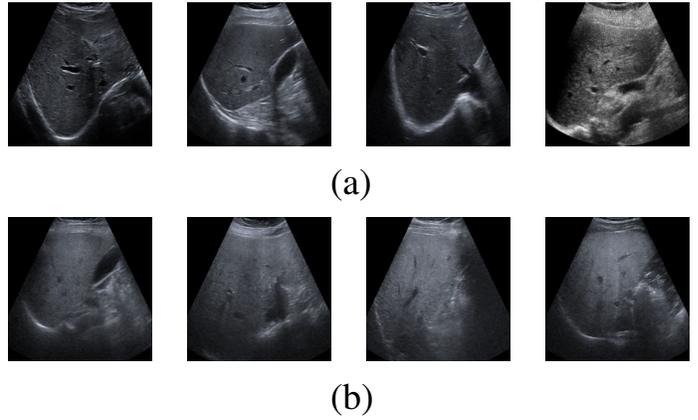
(a) Ultrasound images of liver under normal conditions, (b) Ultrasound images of liver under fatty liver conditions.
